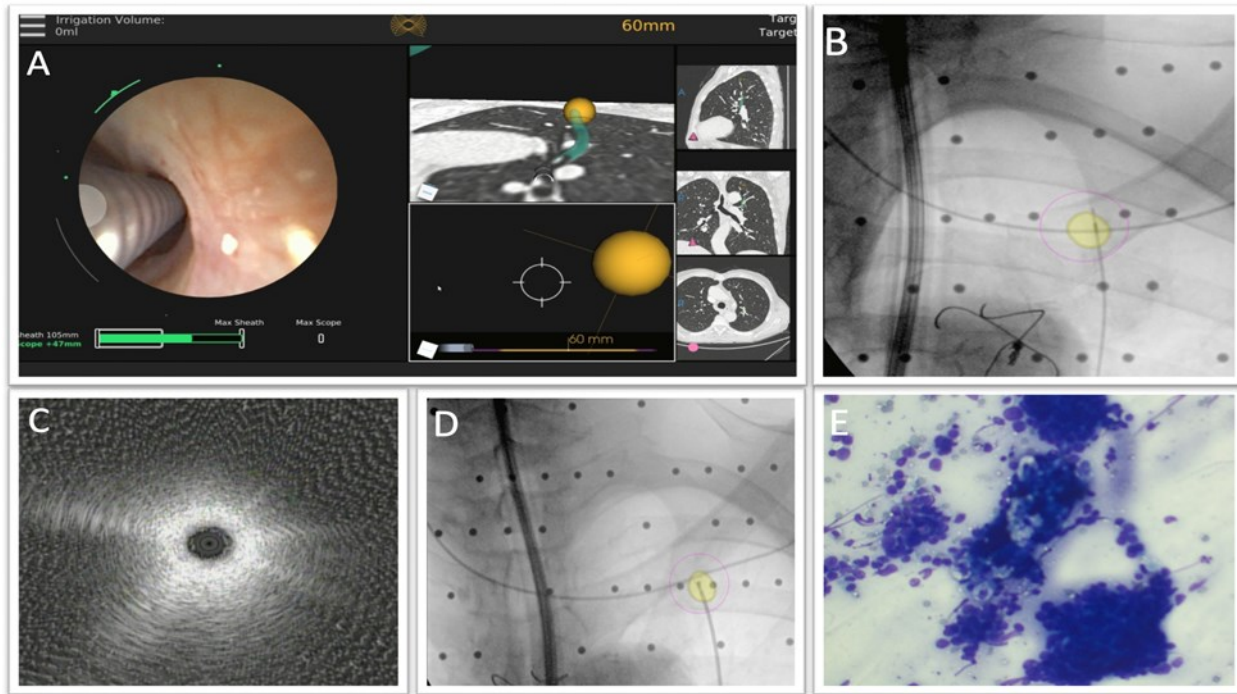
A: Robotic bronchoscopy Navigation, B: Radial EBUS advanced to the location of the nodule as determined on the CABT images post registration (Yellow spot marks the nodule), C: Radial EBUS advanced to the lesion but no ultrasonographic imaging of the nodule obtained, D: Biopsy of the nodule with forceps, E: Rapid onsite evaluation of the nodule biopsy showing non-small cell lung cancer with final path revealing poorly differentiated squamous cell lung cancer.
